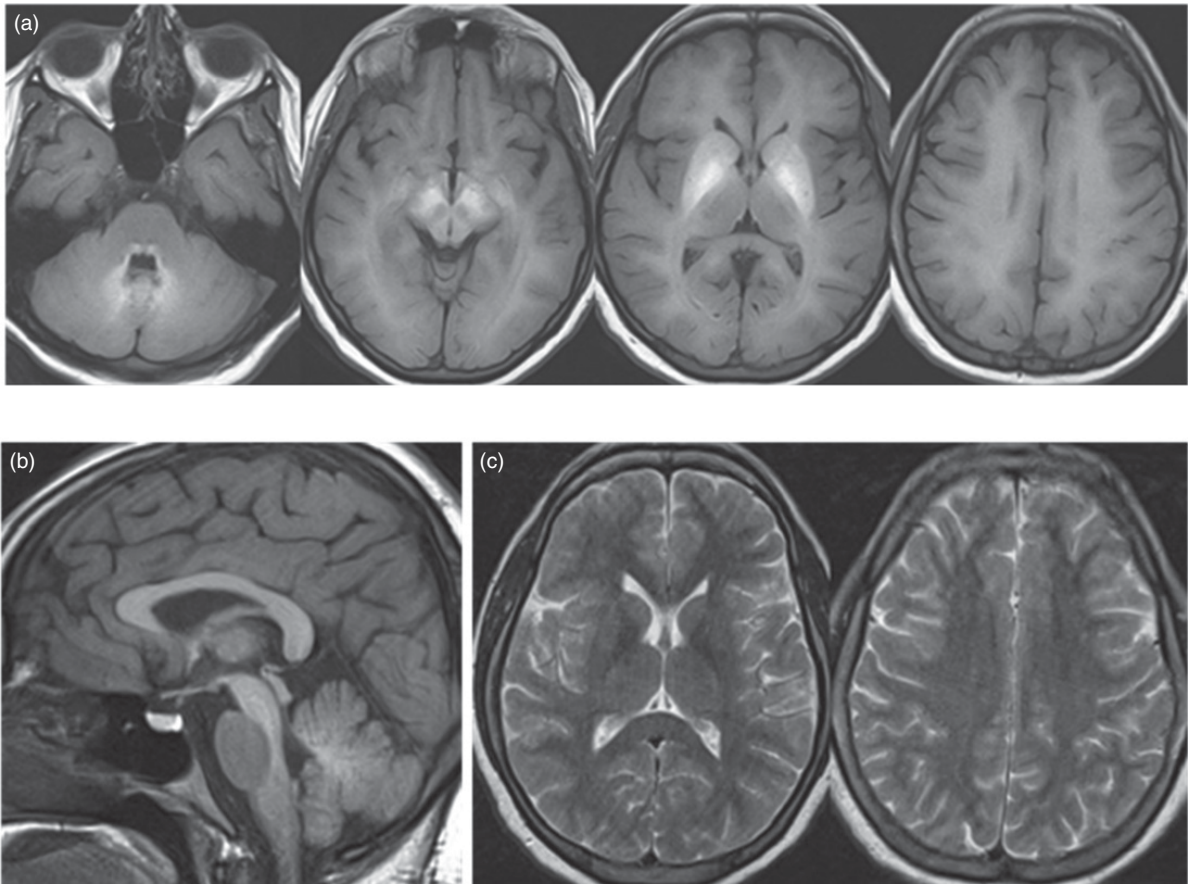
MRI brain appearances in *SLC30A10* deficiency: T1-weighted MRI shows abnormally high signal on (a) transaxial images from the white matter, putamen, and globus pallidus bilaterally; and (b) on sagittal images from the anterior pituitary and white matter, particularly the corpus callosum, midbrain, dorsal pons, and medulla. (c) Transaxial T2-weighted images show abnormally low signal from the globus pallidus in the same distribution as the regions of highest signal on the T1-weighted images. From: Tuschl K, Clayton PT, Gospe SM Jr et al. Syndrome of hepatic cirrhosis, dystonia, polycythemia, and hypermanganesemia caused by mutations in *SLC30A10*, a manganese transporter in man. *Am J Hum Genet.* 2012; 90:457–66.
